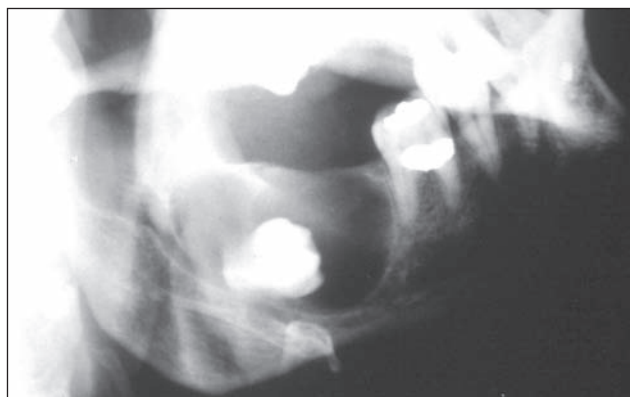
Radiograph of an odontogenic keratocyst that has enveloped an unerupted tooth to produce a 'dentigerous' appearance.
